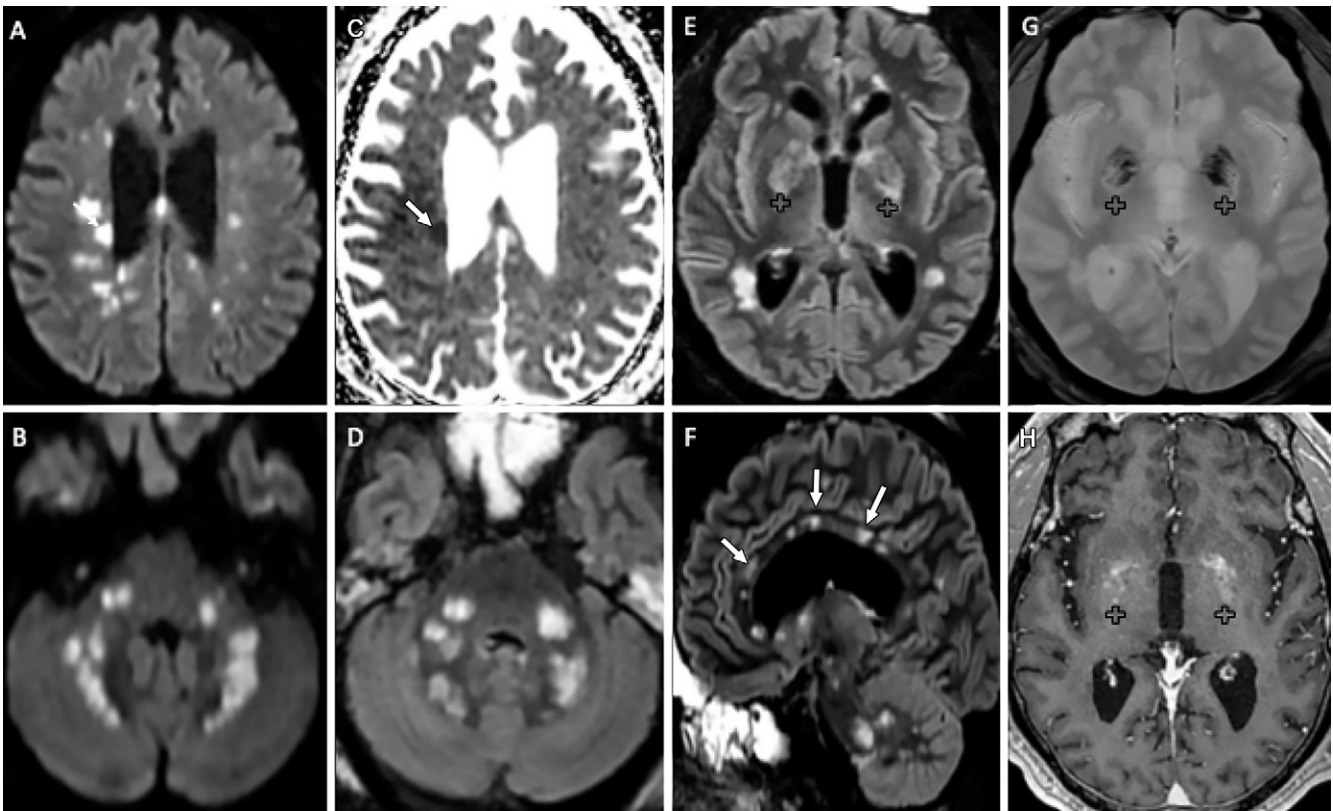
Images in a 65-year-old man with abnormal wakefulness after sedation. Nonconfluent multifocal white matter hyperintense lesions on fluid-attenuated inversion recovery (FLAIR) and diffusion, with variable enhancement, and hemorrhagic lesions. A, B, Axial diffusion-weighted images; C, apparent diffusion coefficient (ADC) map; D, E, axial FLAIR images; F, sagittal FLAIR image; G, axial susceptibility-weighted image; and H, contrast-enhanced T1-weighted MRI scan. Multiple nodular hyperintense diffusion and FLAIR lesions localized in the white matter including the F, corpus callosum. Some (arrows) are associated with reduced ADC corresponding to C, cytotoxic edema. E, G, H, Other lesions are located next to the lenticular nucleus (+), with G, hemorrhagic changes, and enhancement after contrast material administration.
